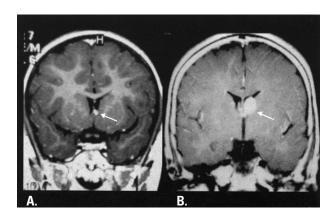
Progressive growth of an enhancing lesion at the foramen of Monro in a tuberous sclerosis complex patient. Coronal T1-weighted image with Gadolinium (A) shows a small enhancing lesion; marked growth in the three-year follow-up (B).
